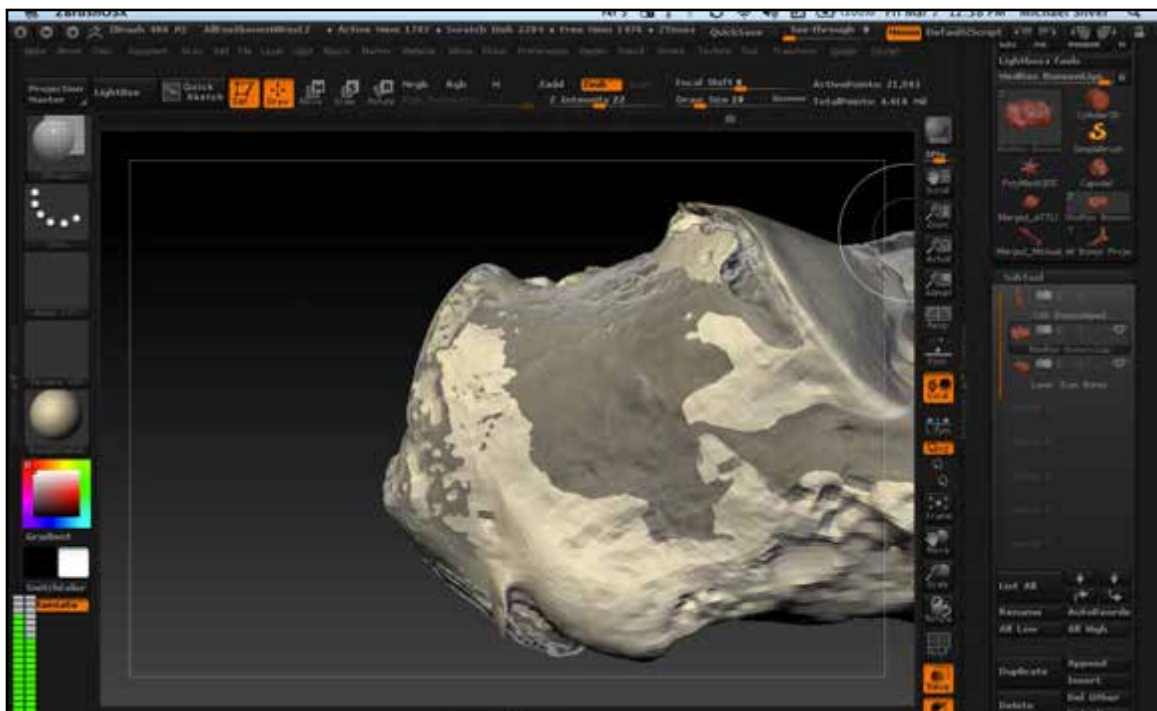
Repaired posterior calcaneus region of CT based mesh.
